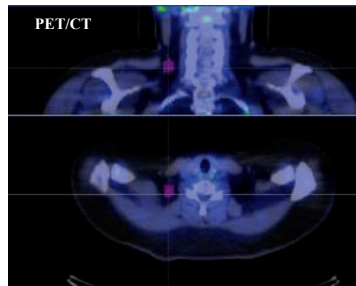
ROIs were symmetrically drawn in the supraclavicular fat depot taking into account the underlying CT-radiodensity (U Din et al., 2016).
